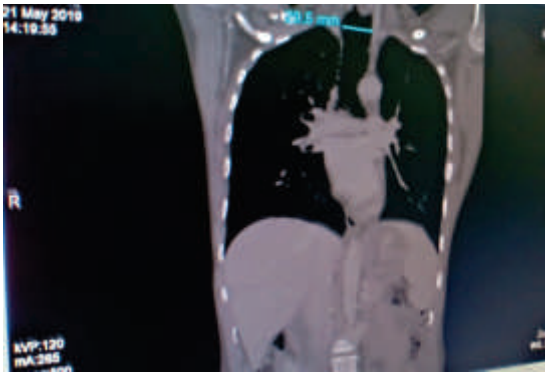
CT Thorax with MPR shows abnormal dilatation of trachea 2.95cm.
